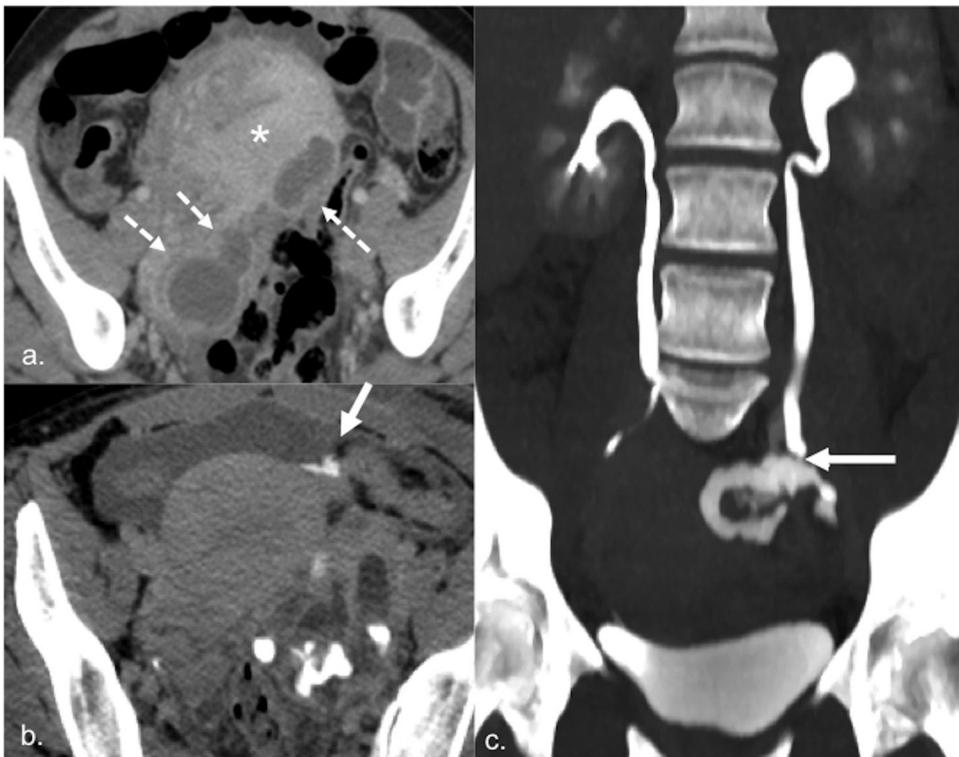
Post-Caesarian pelvic abscesses and ureteral damage. (a) Pelvic abscesses in contact with the posterior uterine wall (dotted arrows) and enlarged puerperal uterus with perfusion disorders (*) in a 35-year-old woman on the fifth day of puerperium. The abscesses were surgically drained, and the postoperative CT scan (b) shows extravasation of contrast in the excretory phase which fills the fluid collections (arrow). The coronal reconstruction (c) identifies the injury of the left ureter (arrow).
